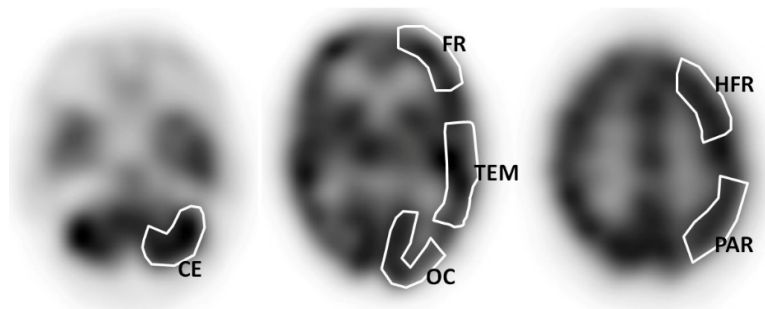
Regions of interest (ROIs) drawn in the different portions of brain perfusion SPECT: Cerebellum (CE); Occipital (OC); Temporal (TEM); Frontal (FR); Parietal (PAR) and High frontal (HFR).
